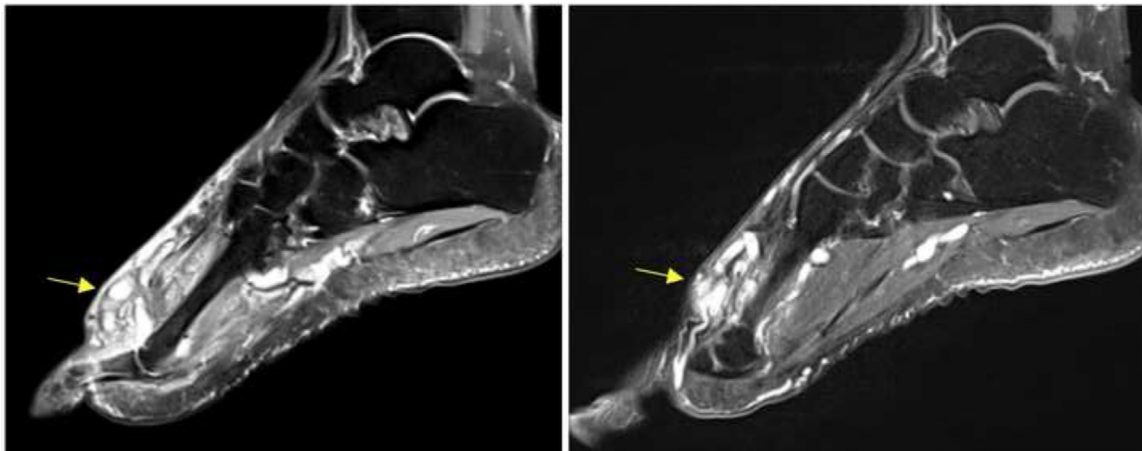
Case 1. Sagittal MRI sections in data proton weighting (A) and fat-suppressed T1 weighting after gadolinium injection (B), showing the previously described mycetoma grains, with infiltration of the adjacent muscles, and intermuscular fascial planes.
